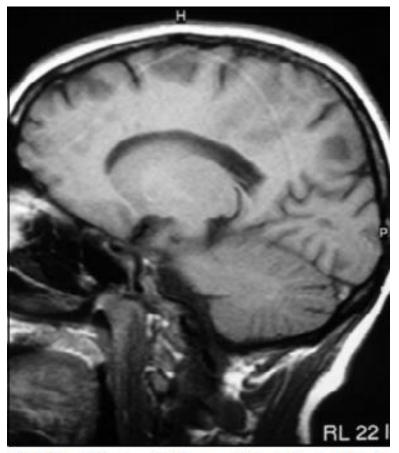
T1-weighted sagital image with irregular signals in the sagitals sinus.
